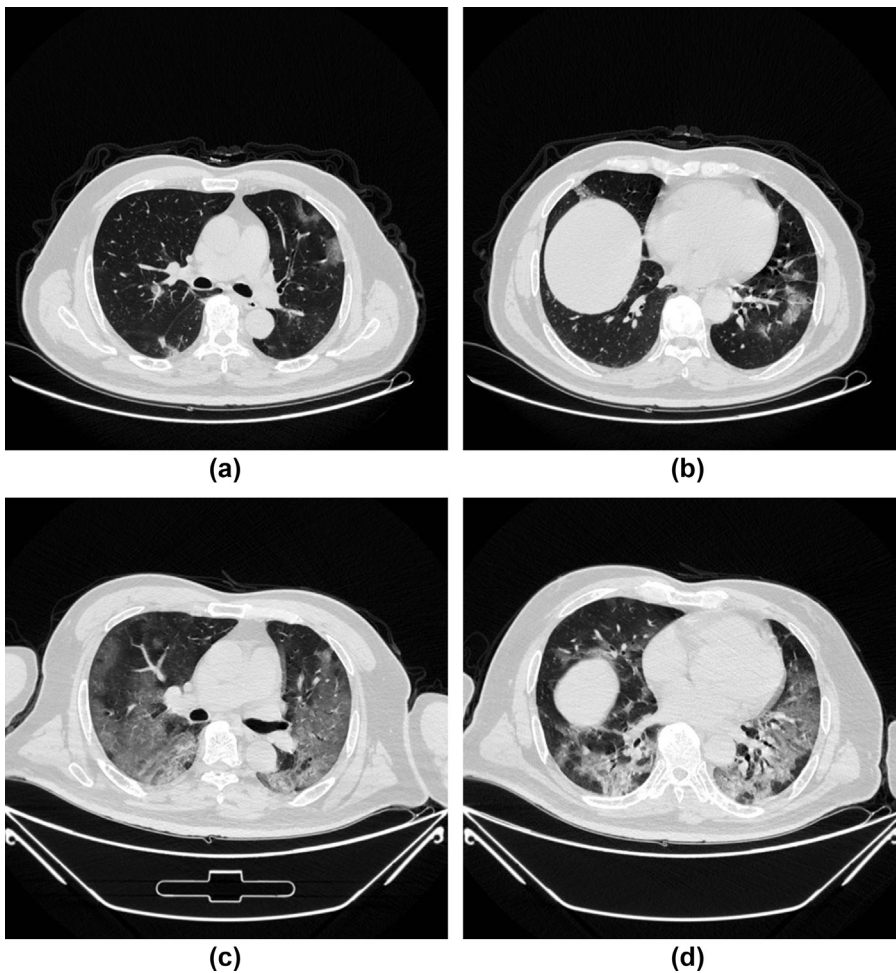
(a,b) Images from two CT examinations in 25 January 2020 and (c,d) 5 February 2020 from a 42-year-old man who had a history of contact with people from Wuhan, and complained of an intermittent fever for 5 days with the highest temperature of 38.9°C.
